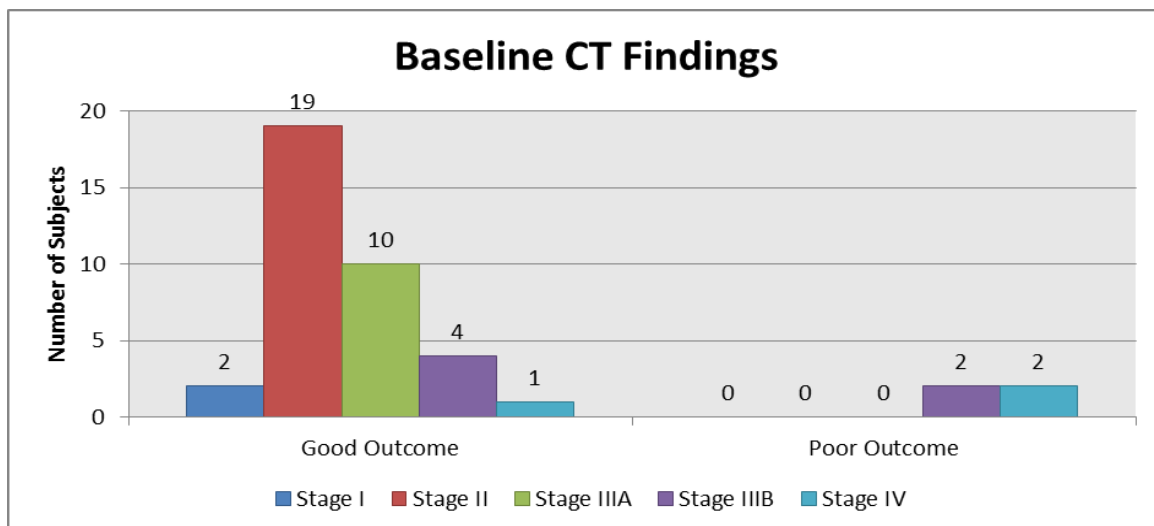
CT classification
